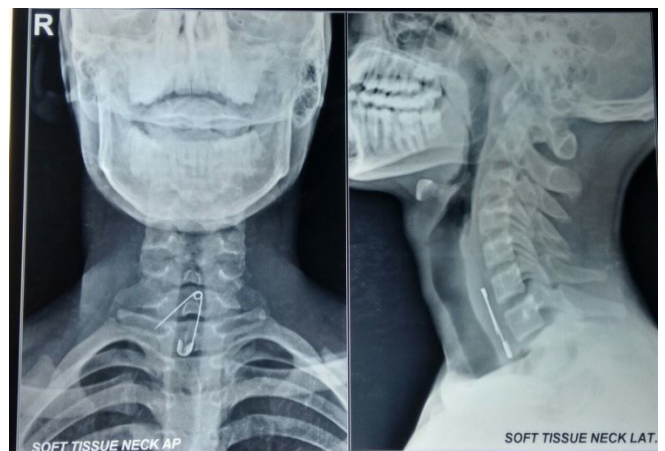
Soft tissue X-ray neck (AP and lateral views) showing open safety pin at the level of C6-C7
